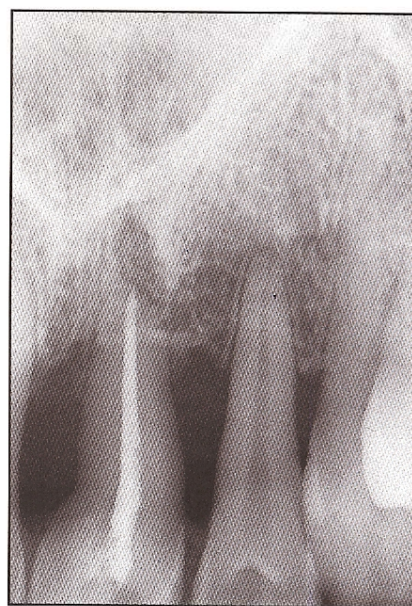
The follow-up radiograph, taken 36 months postoperatively, reveals the partial restoration of periodontal structures.
